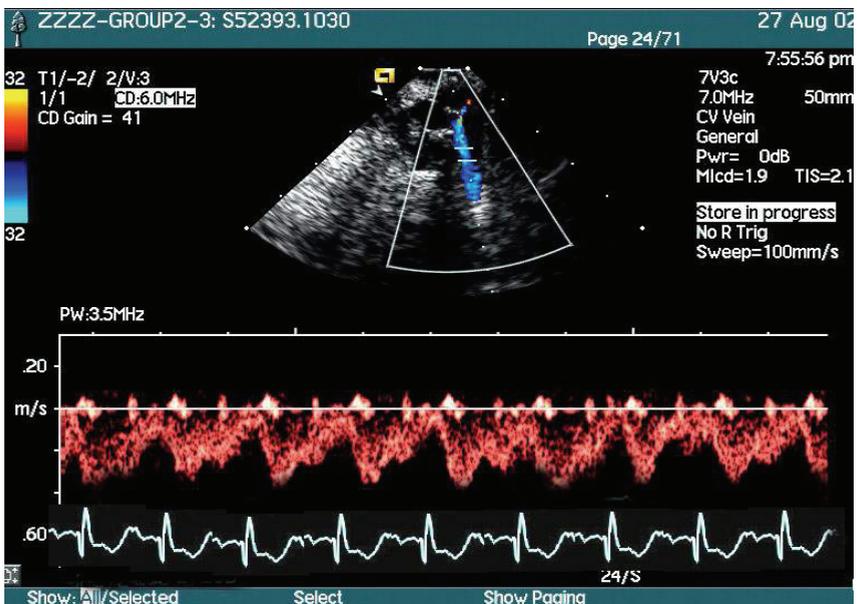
SVC Doppler flow velocities decreased after radiotherapy from the same patient shown in figure 11
